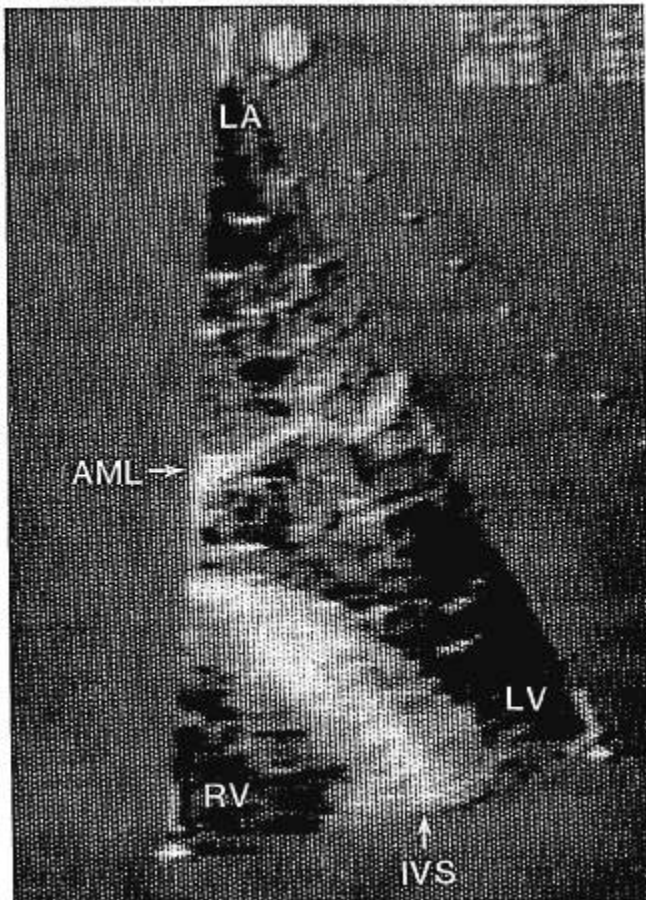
Right-to-left interatrial shunting after protamine administration. Long-axis four-chamber view at end diastole showing echocardiographic contrast in the left atrium and ventricle diagnostic of right-to-left interatrial shunting. The contrast agent is presumed to be microbubbles created during rapid injection of medication into the right atrial port of the pulmonary artery catheter and appears as specular echoes within the cardiac chambers. No intracardiac microbubbles were visualized during the initial period after separation from cardiopulmonary bypass. LA = left atrium; RV = right ventricle; LV = left ventricle; AML = anterior mitral valve leaflet.
